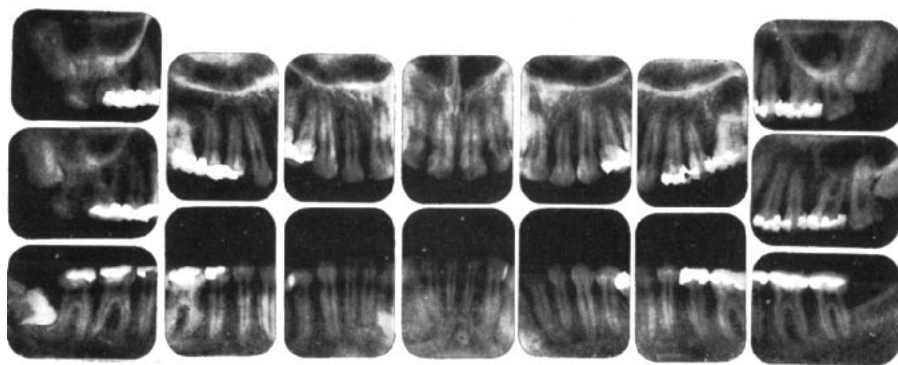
Full mouth roentgenogram following treatment. (November, 1939)
